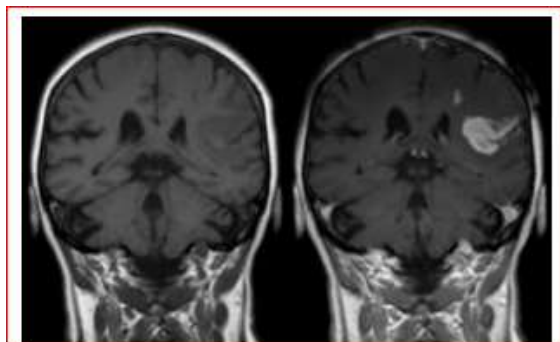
Effect of contrast agent on T1-weighted images. Left image without, right image with contrast medium administration
